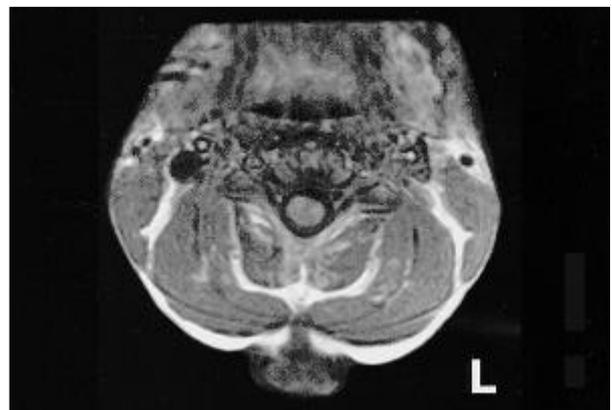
Dermoid sinus is delineated on T1-weighted axial MR image.
